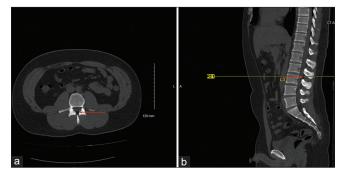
(a) Axial CT lumbar spine demonstrated air in the spinal canal at L3 without compression of the thecal sac. (b) Sagittal CT lumbar demonstrated air in the spinal canal extending from the lumbar region to the lower thoracic spine at the upper limit of the scan.
